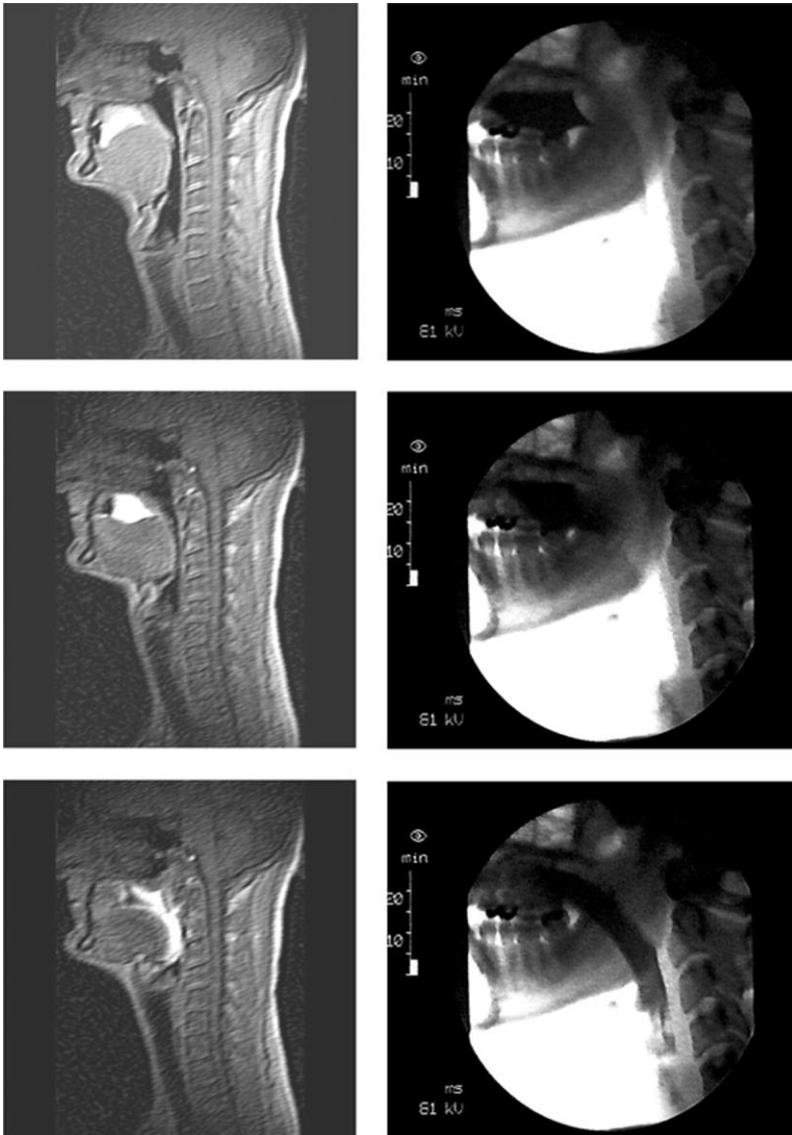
Oral and pharyngeal segments of a subject. Dynamic sequence in the sagittal view shows a normal peristaltic wave with propagation of the bolus. Upper: during rest; middle: at the beginning of swallowing; below: complete swallowing (velopharyngeal closure prevents nasal penetration). Left: videofluorography images; right: magnetic resonance images.
